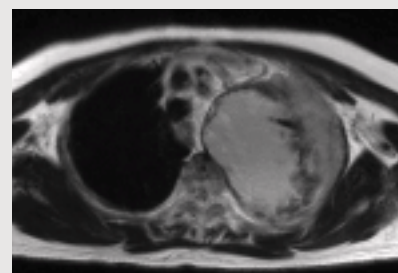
T2-weighted image
